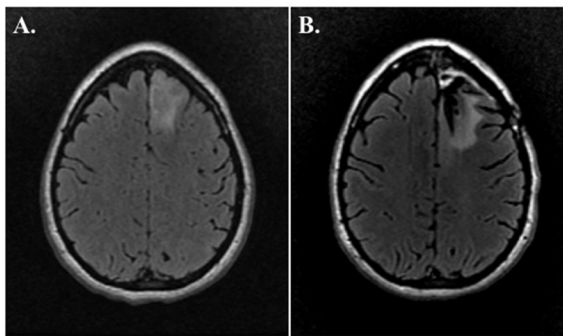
Radiologic images of initial and recurrent tumor. MRI-brain with contrast performed in 2014 (A) and 2019 (B) revealed a nonenhancing abnormal signal in the left frontal lobe, suggestive of the initial primary glioma and later recurrence, respectively (A, B, Axial FLAIR).
